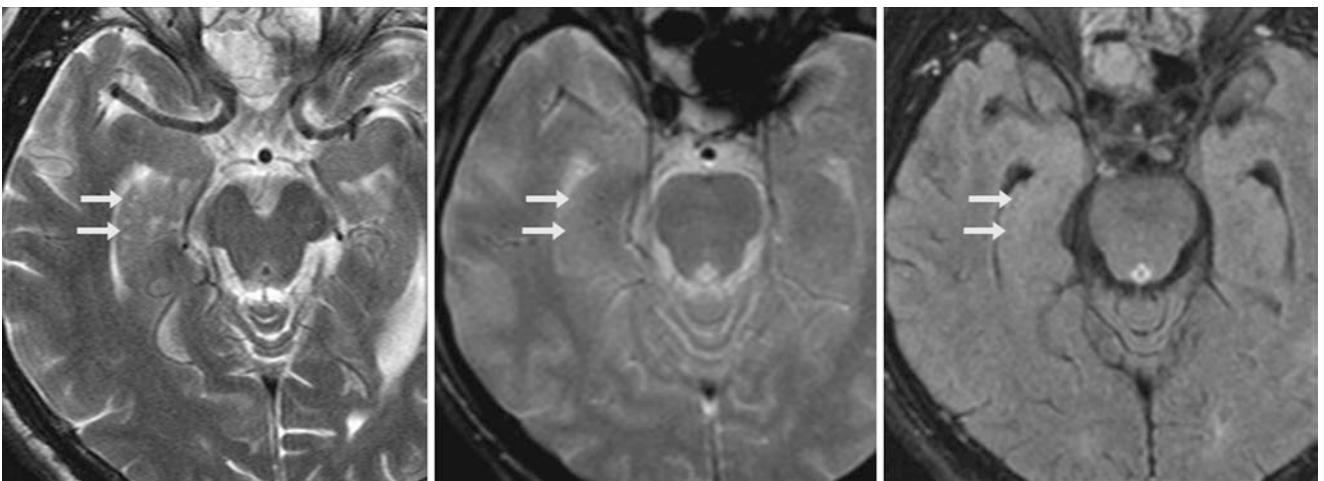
A 50 year old had multiple tiny right hippocampal cysts (*arrows*) that were visualized on a 1.5 T axial T2WI (*left*) but are basically invisible at the same slice thickness on axial T2* GE (*middle*) and on FLAIR (*right*) MR images
